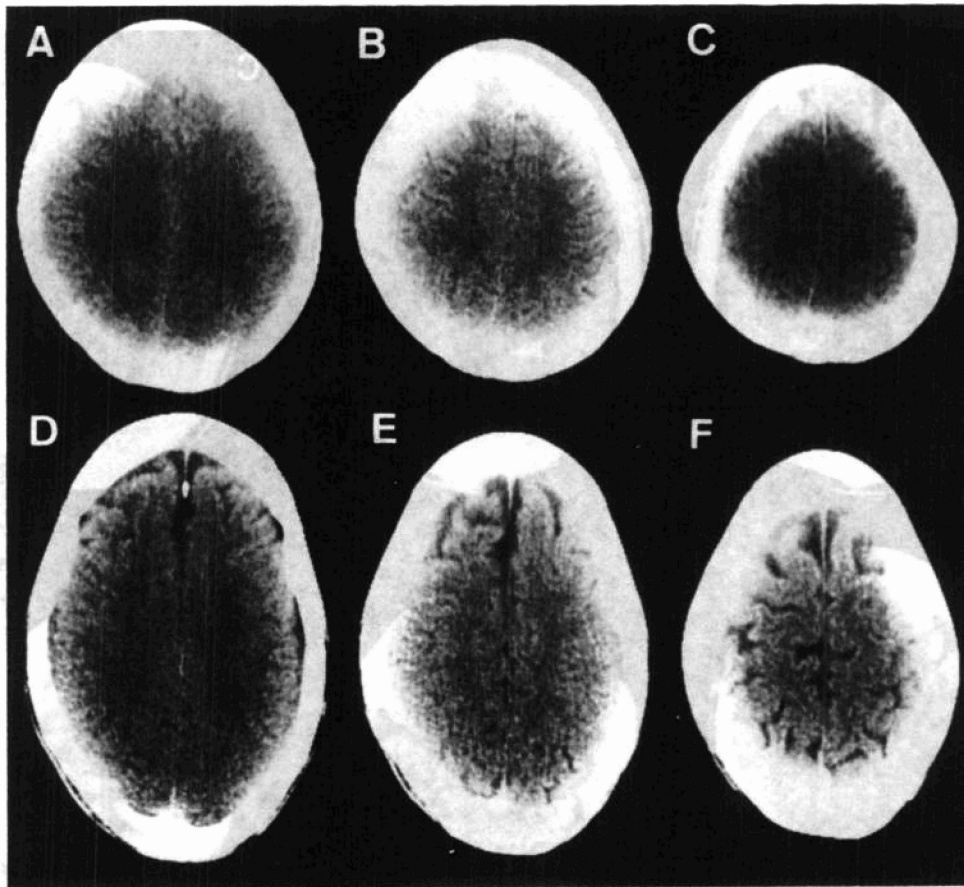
CT scans demonstrating the upper frontoparietal regions in a normal 30 year old man (A-C) and the corresponding CT scans of a 27 year old schizophrenic patient (D-F) with wide frontal sulci and a wide frontal part of the interhemispheric fissure.
